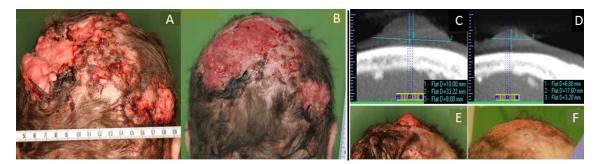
A: laBCC of patient 1 before high dose IVA treatment at week 0, B: and at week 75, respectively. C-D: CT scans and D-F: clinical photos of a target lesion on the scalp of patient 1 before (week 0) and after (week 75) IVA therapy.
